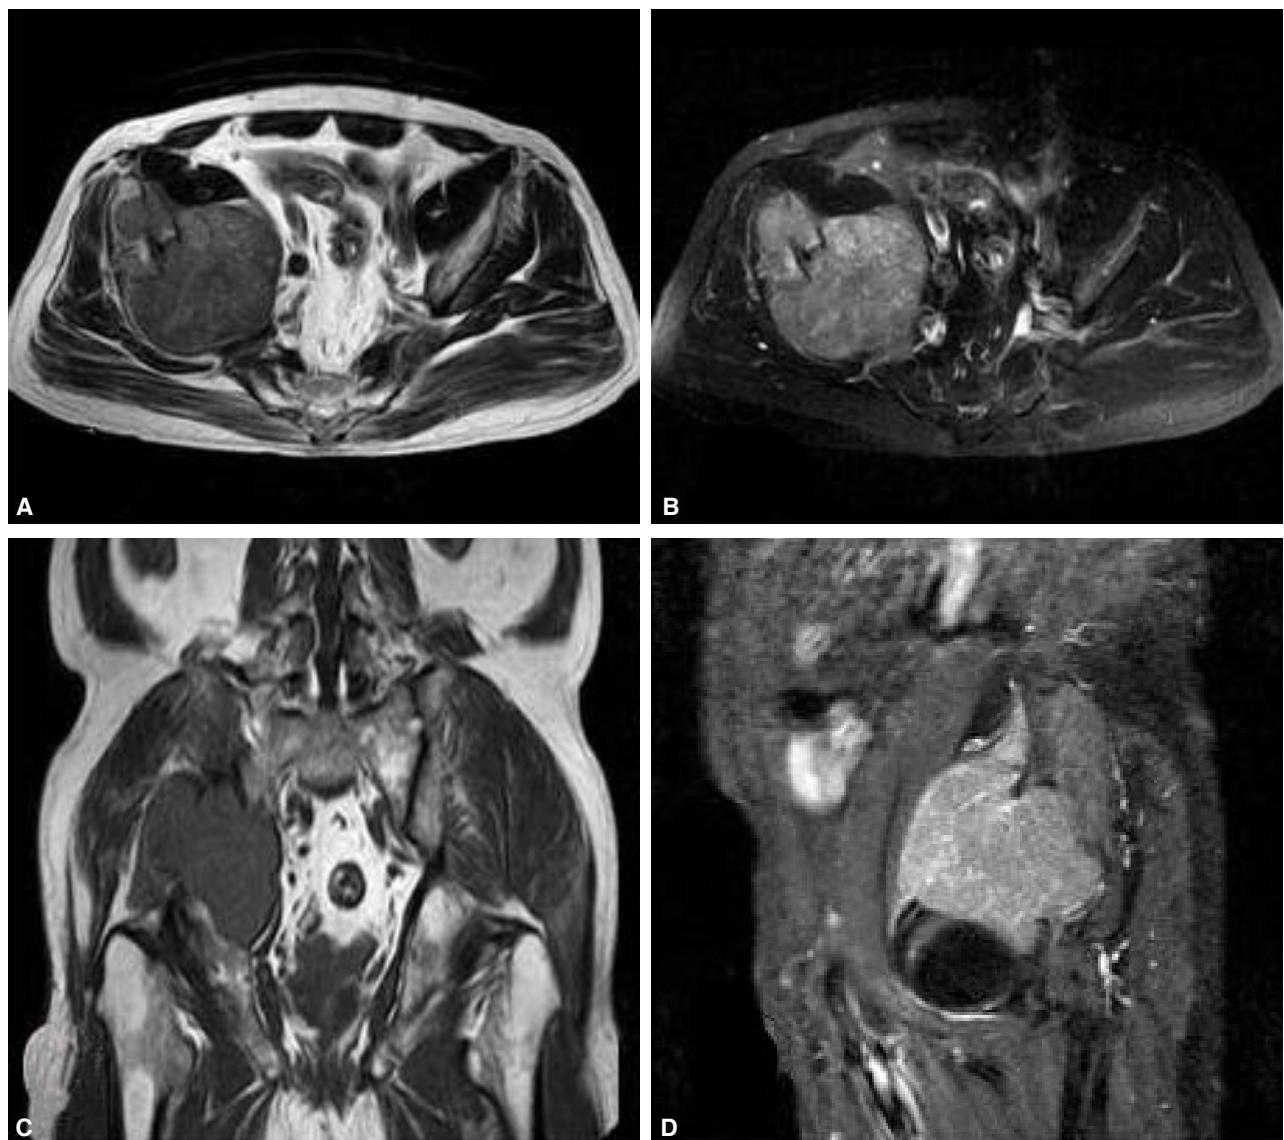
Pelvic magnetic resonance imaging (MRI). A 13 \times 10-cm bone mass was found in the right iliac bone. (A, C, D: T1-weighted images, B: T2-weighted image).
